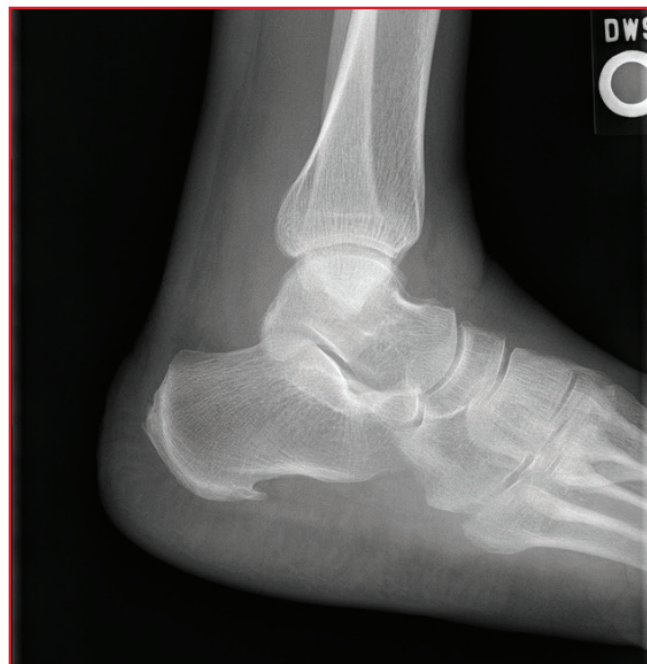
Lateral ankle radiograph of the patient on presentation demonstrating a small joint effusion.
